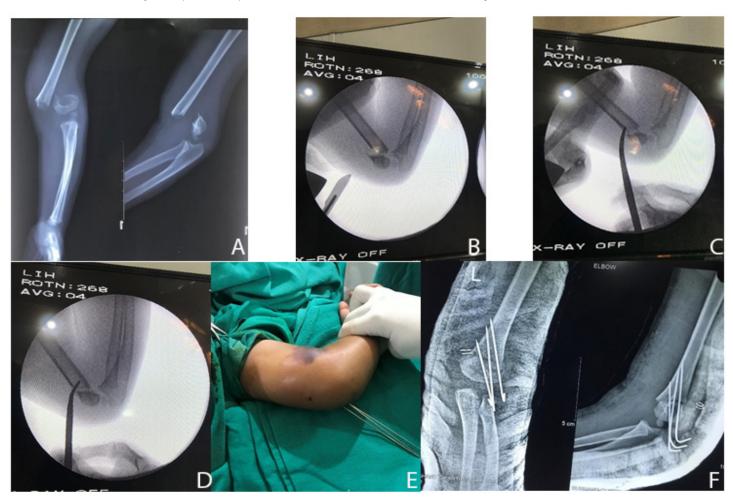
Preoperative Xray of type III supracondylar fracture of humerus in 5 years old child (A); Giving a nick on posterior aspect of elbow with a knife after unsuccessful attempts of reduction of fracture (B); Insertion of artery forceps through the nick and try to reduce the fracture (C); Complete reduction of fracture with artery forceps (D); Small wound on skin after fixation with three K wires (E); Post-operative X-ray AP and Lateral view after fixation with K wires (F)
